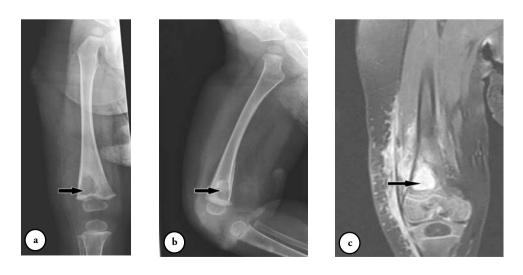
Radiological assessment of the third patient a) AP, b) lateral x-ray views, and c) MRI showing a lytic lesion (b arrows) in the distal right femur with soft tissue extension.
